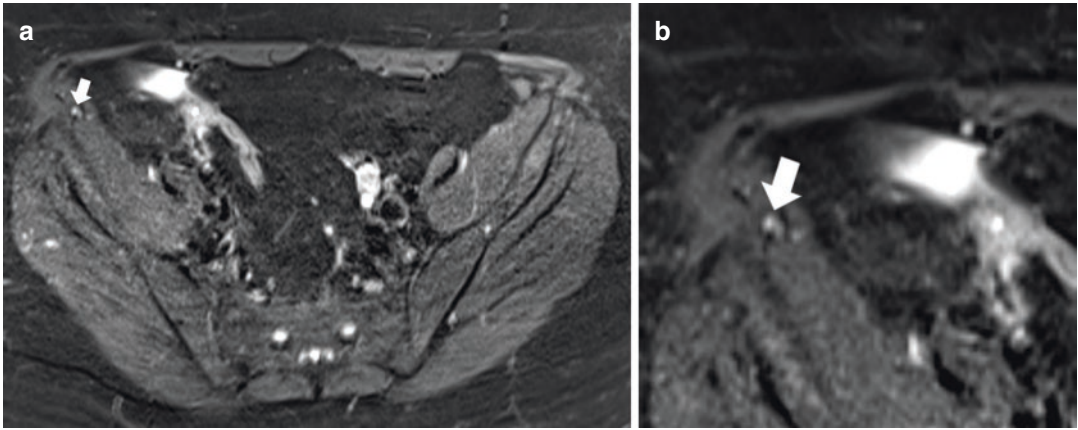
(a, b) Lateral femoral cutaneous neuropathy in a 53-year-old woman with symptoms of meralgia paresthetica. (a, b) Axial fat-suppressed T2-weighted image
